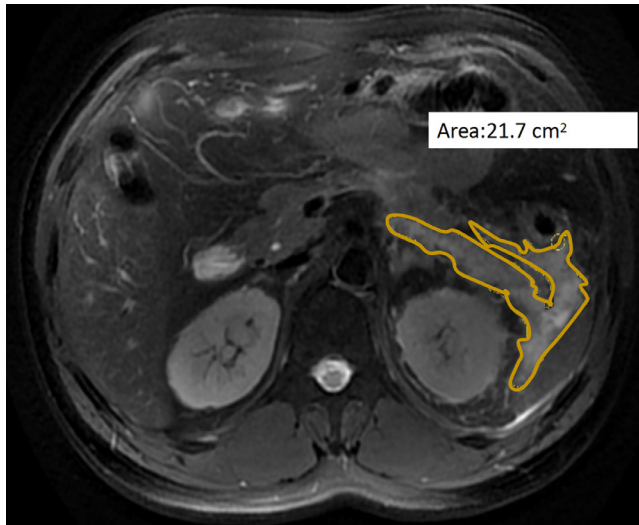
Interstitial edematous pancreatitis with APFC in a 44-year-old man. On axial fat-saturated T2-weighted MR images, the area of extrapancreatic collections (AEPC) was manually drawn along the margin of collection, and the value of this area (21.7 cm^2) was automatically derived by software.
